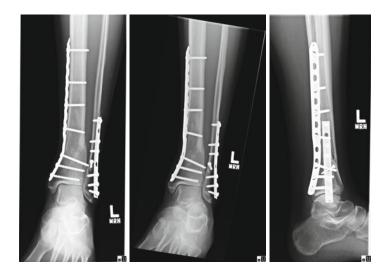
5-month post-operative radiographs
